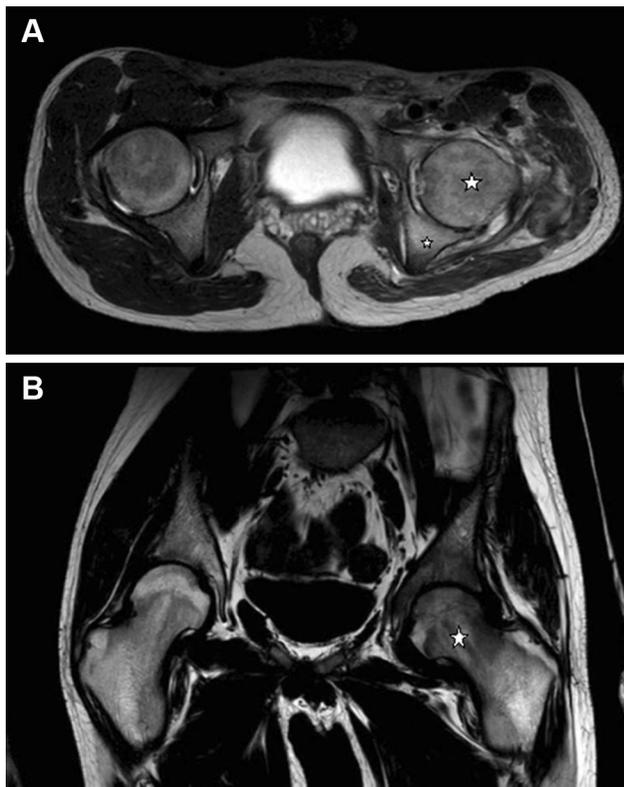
a Axial T2-weighted MRI image at initial presentation. Note the high signal intensity within the femoral head and acetabulum (asterisks), the cartilage thinning, the small joint effusion and the marked gluteal atrophy. b Coronal T1-weighted MRI image also showing the altered signal intensity within the femoral head (asterisk)
